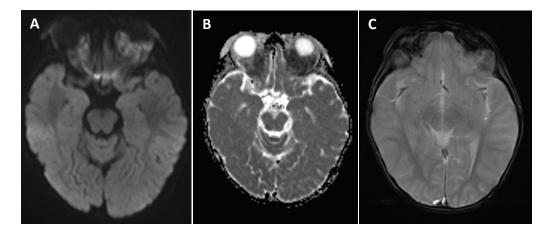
(A) Diffusion weighted imaging (DWI) with (B) apparent diffusion coefficient (ADC) maps and (C) susceptibility weighted imaging (SWI) MRI sequences showing restricted diffusion with loss of signal in SWI of the masses occupying the superior extraconal regions of both orbits
